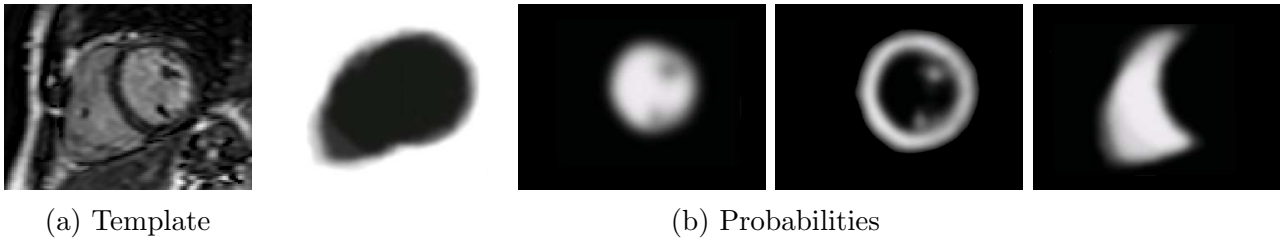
A probabilistic atlas provides a probability map for each of the labels in a template space. In this case, we have the probabilities for the background, left ventricle, myocardium and right ventricle in cardiac MRI. Probabilities are shown as proportional to intensity.
